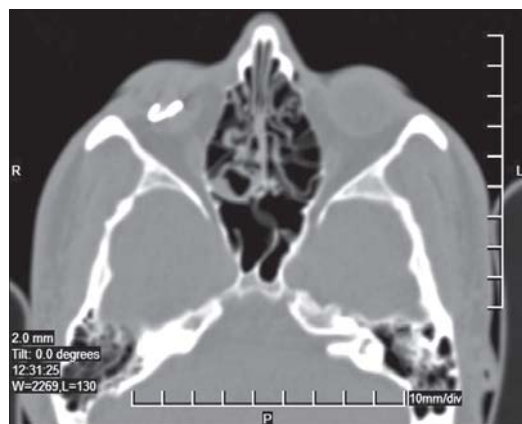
CT scan showing the presence of IOFB (Courtesy: Dr MS Bajaj, R P Centre, New Delhi)
